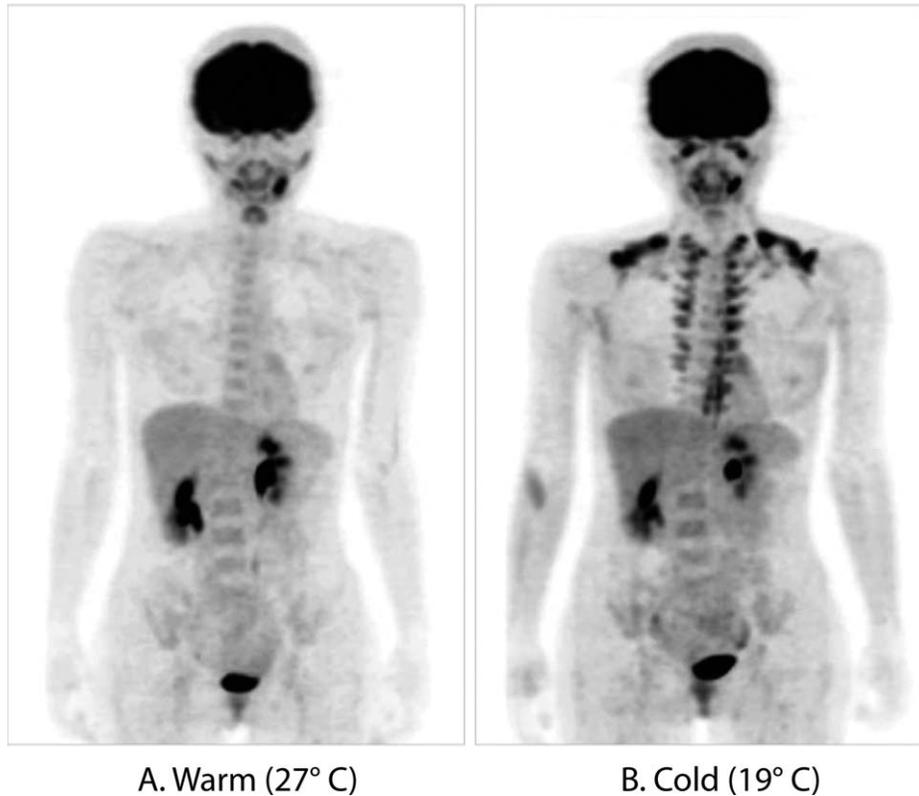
Human brown adipose tissue detected by fluorodeoxyglucose (FDG)-positron emission tomography (PET). FDG uptake into adipose tissue at the supraclavicular and paraspinal regions is detected by PET. The FDG uptake into adipose tissues is negligible under a warm condition at 27°C (A), but increases greatly after exposure to cold at 19°C (B) for 2 h. Reprinted from Fig. 2 in Saito M, *Diabetes Metab J.* 2013 Feb;37(1):22–29. Copyright © 2013 Korean Diabetes Association, Open Access under the terms of the Creative Commons Attribution Non-Commercial License.
